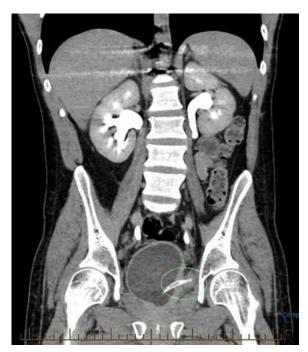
Image from CT abdomen and pelvis 10th August 2024: Indwelling catheter in situ with focal thickening along left bladder wall. The tip of the catheter appears to extend 11 mm beyond the serosal surface of the bladder, with adjacent inflammatory change.
